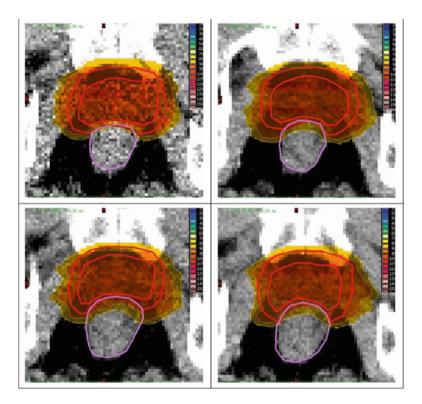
Variation of the anatomy due to interfractional motion and the corresponding dose distributions for a carbon ion boost of a prostate carcinoma patient. The CT data were taken as reference and planning image (*upper left*) and as control scans taken on three different days during the prior irradiation with photons using an in-room CT scanner on rails (*upper right* and *two lower images*). The doses were calculated on these control CTs using the applied treatment plan. The analysis of the distributions shows the mean difference (standard deviation of the 95%- and 90%-coverage for the gross tumor volume (GTV) of 4.9% (SD 3.6) and 2% (SD 1.5), respectively. The corresponding values for the clinical target volume (CTV) were 3.6% (SD 3.7) and 2.8% (SD 2.8), respectively. Data from [12]
